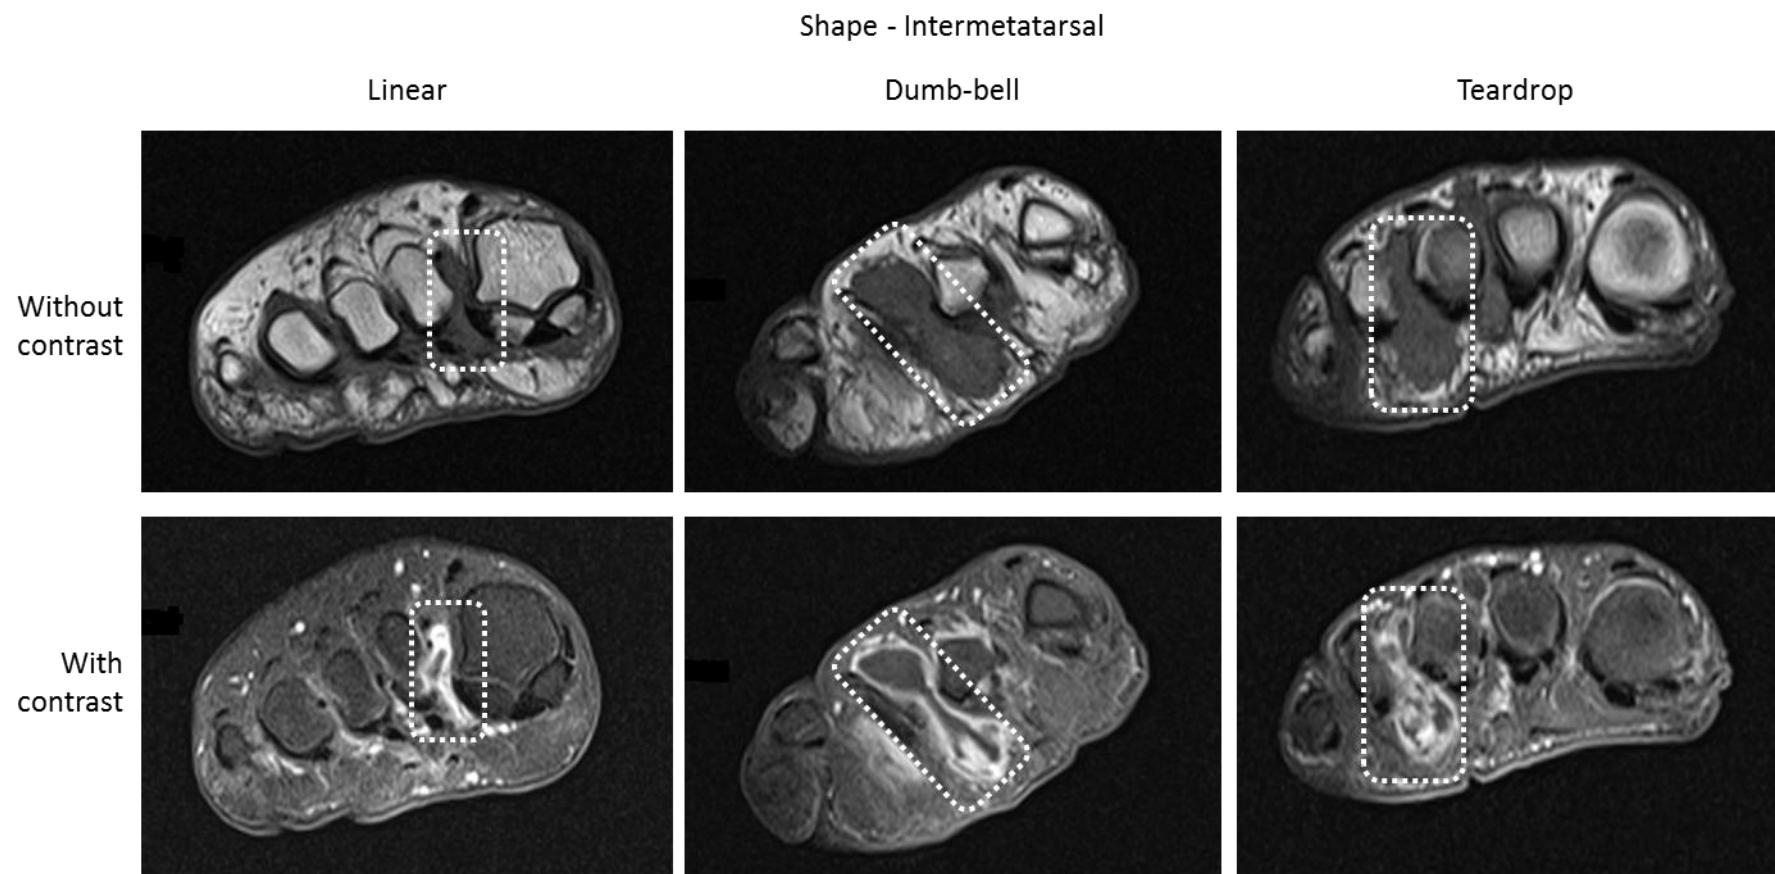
Differences in MRI-detectable FFB shape
